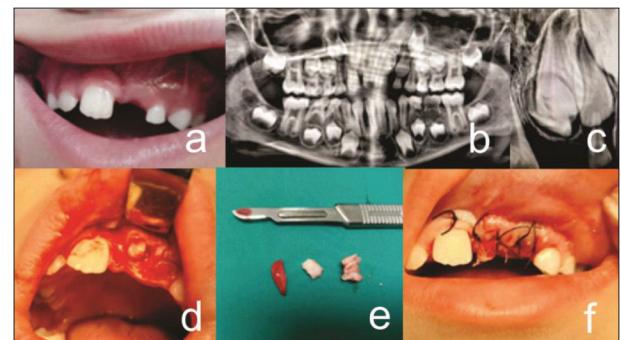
Unerupted tooth 21 (a – clinical appearance, b – X-ray, c – X-ray, d – extraction site, e – extracted supernumerary tooth, d – post-extraction suture)
